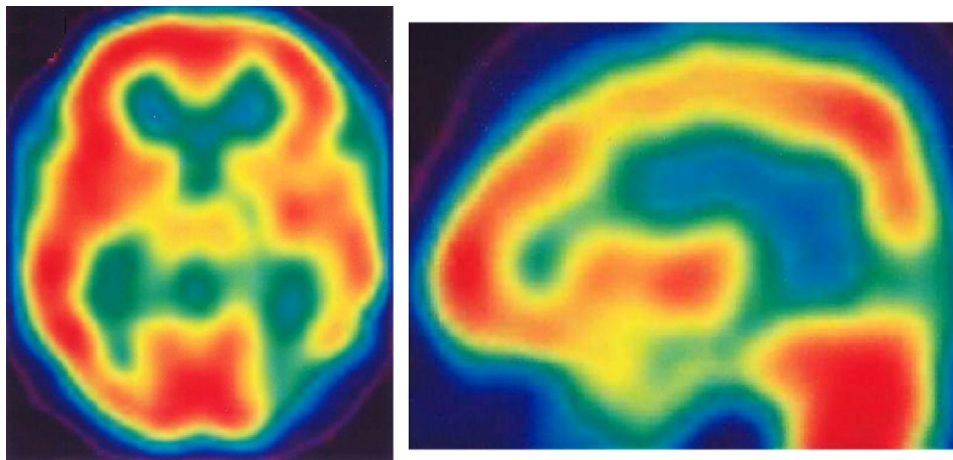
Axial (on the left) and left paramedian sagittal (on the right) brain SPECT scans showing reduced blood flow in the inferior and lateral cortex of the left occipital lobe (regional blood flow reduced by 25.8% with respect to contralateral cortex).
